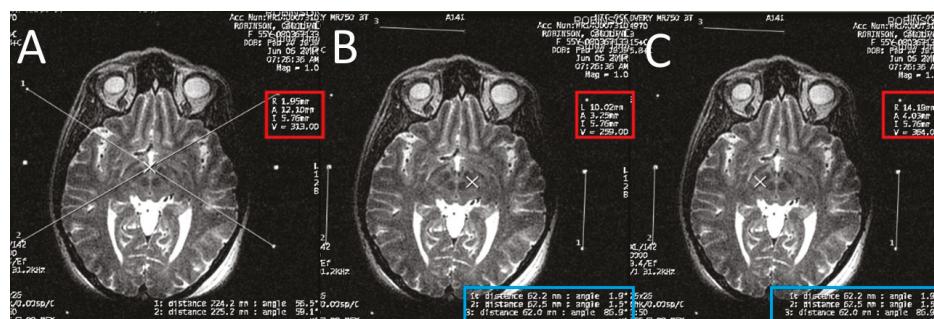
Calculating the subthalamic nucleus (STN) coordinates from the magnetic resonance imaging (MRI) console. (A) two diagonal lines intersecting at the center of the frame at the STN level with MRI coordinates of the center of the frame shown inside the red square; (B) a crosshair at the center of the left STN, with its MRI coordinates shown inside the red square, two line are drawn between the middle and lower fiducials on both sides of the frame and their lengths (in the blue rectangle) are used to calculate the Z coordinate; (C) a crosshair at the center of the right STN, with its MRI coordinates shown inside the red square, two line are drawn between the middle and lower fiducials on both sides of the frame and their lengths (in the blue rectangle) are used to calculate the Z coordinate.
